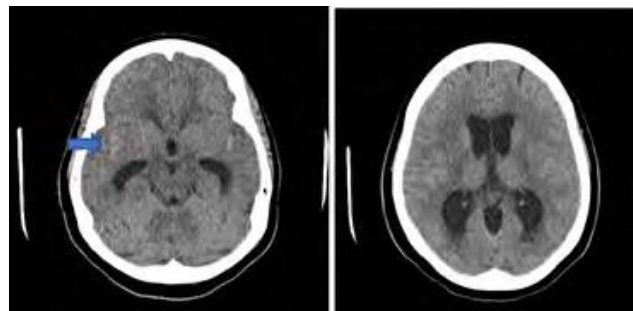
CT imaging showed: Subtle hyper densities in bilateral sylvian fissures are suspicious for mild sub arachnoid hemorrhage.
